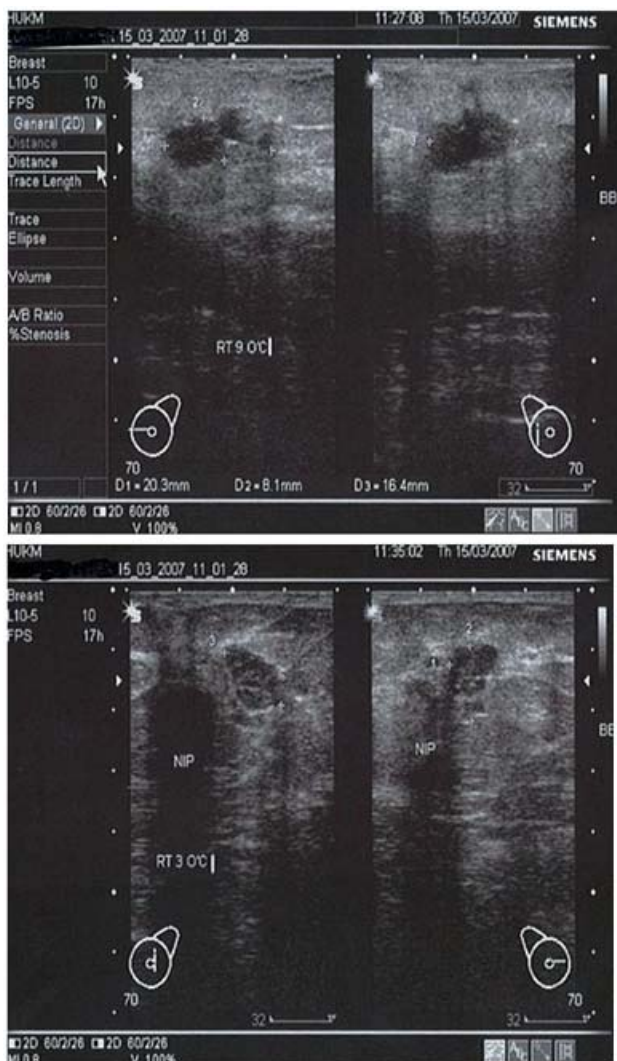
Ultrasound: Irregular mass with acoustic shadow at right 9 o'clock and another well-defined solid mass with irregular margin at 3 o'clock position.
